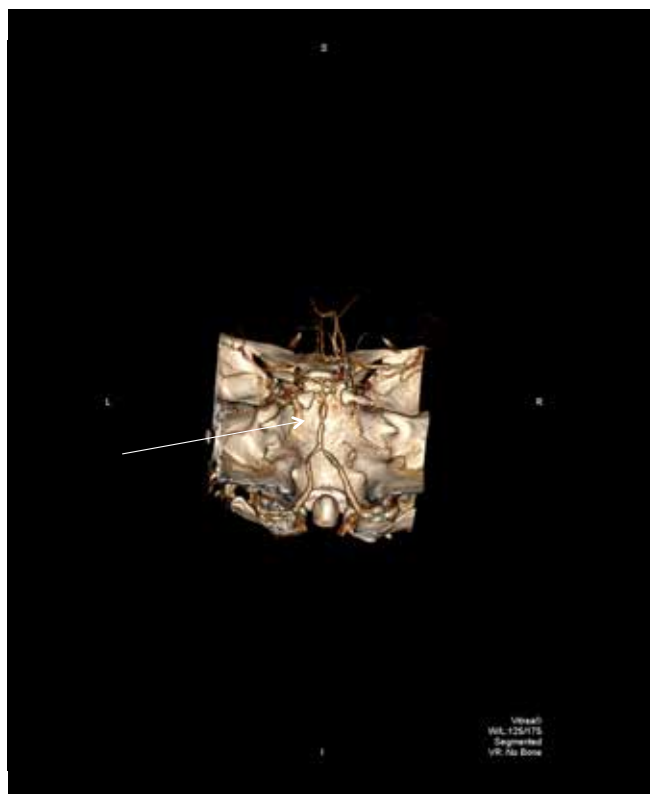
Man in his 30's with sudden severe headache associated with sexual activity. CT Angiogram reconstruction shows marked basilar artery segmental narrowing (arrow) which subsequently resolved at follow up. Consistent with the Reversible Cerebral vasoconstriction Syndrome.
